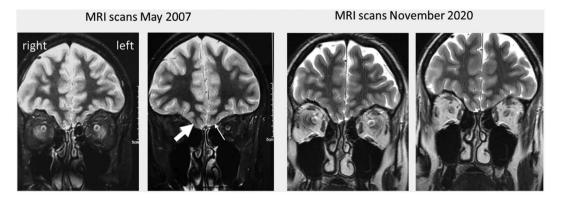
Patient MRI scans at age 12 and a recent visit after regaining smell function (age 25). Clear, but flattened olfactory sulcus on the right hemisphere is visible while the sulcus is flattened on the left. At both occasions, no clearly defined olfactory bulbs could be detected.
